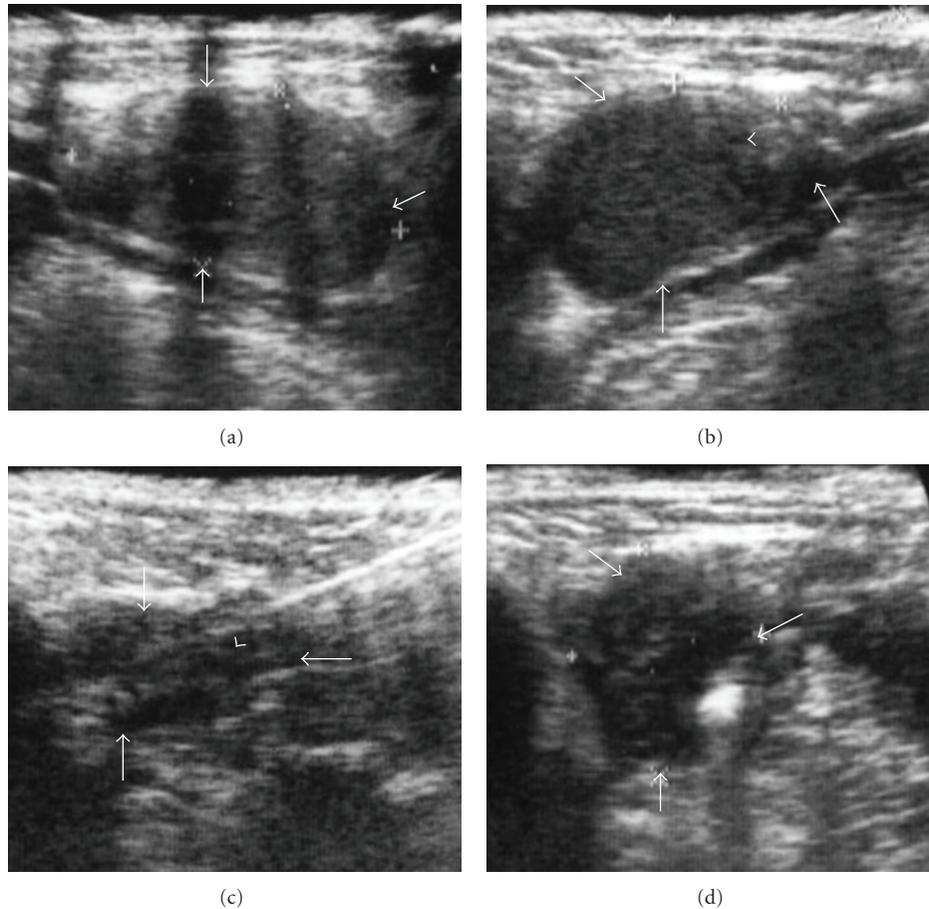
(a) An ultrasound image showing a mass in the right ranula of a 10-year-old girl. (b) An ultrasound image showing the successful penetration of a needle (arrowhead) in a syringe into the ranula (arrows). (c) An ultrasound image showing the decreasing mass (arrows) by aspiration using a syringe. The arrowhead indicates the needle. (d) An ultrasound image showing the increasing mass (arrows) by administration of OK-432 using a syringe.
